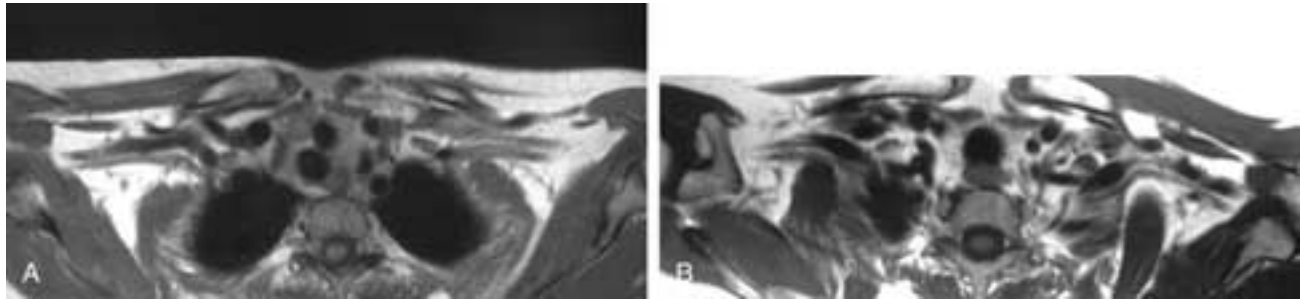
Body coil. Axial T1-weighted MR images at comparable levels using a body coil (A) and a phased array coil (B). Both images are of diagnostic quality. Image B was obtained in two thirds of the time required for image A. Note the detail in the axilla.
